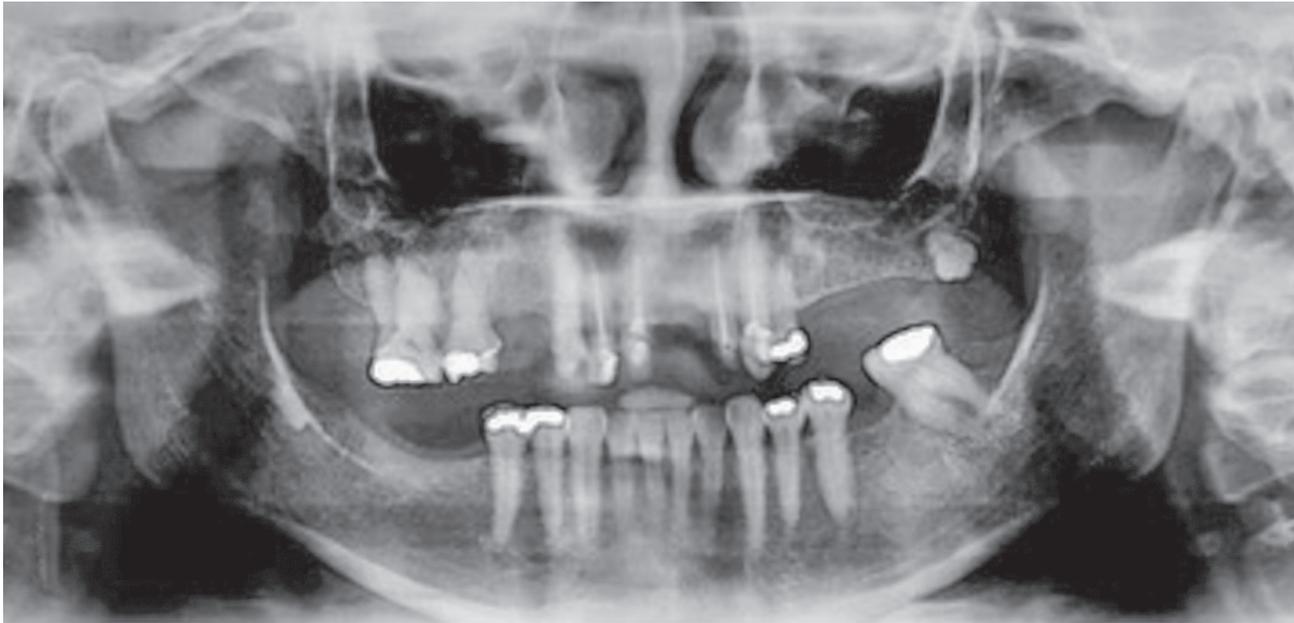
Initial panoramic radiograph.
